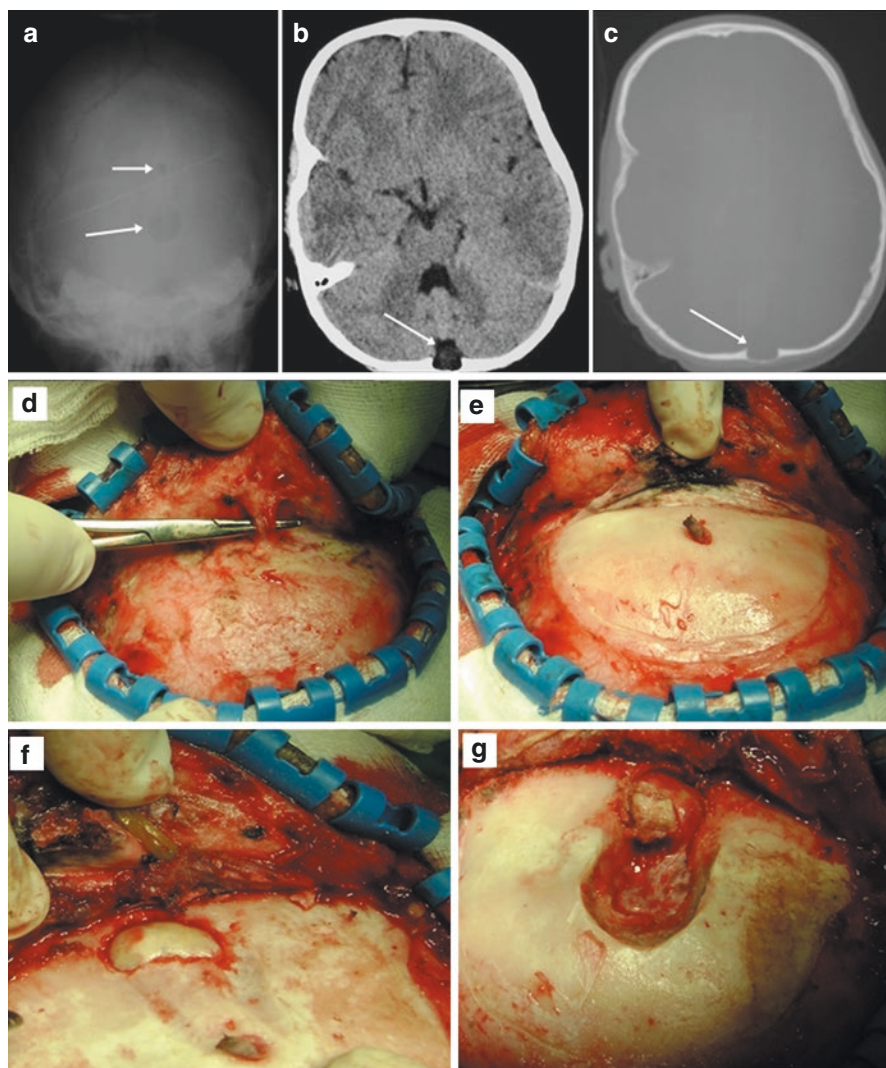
(a) Dermoid cyst. Anteroposterior X-ray (Towne view) showing two osteolytic regions (arrows) of a dermoid cyst with a dermal sinus. (b) and (c) Computed tomography (CT) showing a midline suboccipital lesion eroding the bone. (d) and (e) Dermoid cyst. Intraoperative images showing the sinus tract (f) Dermoid cyst capsule. (g) Total resection of the dermoid cyst
